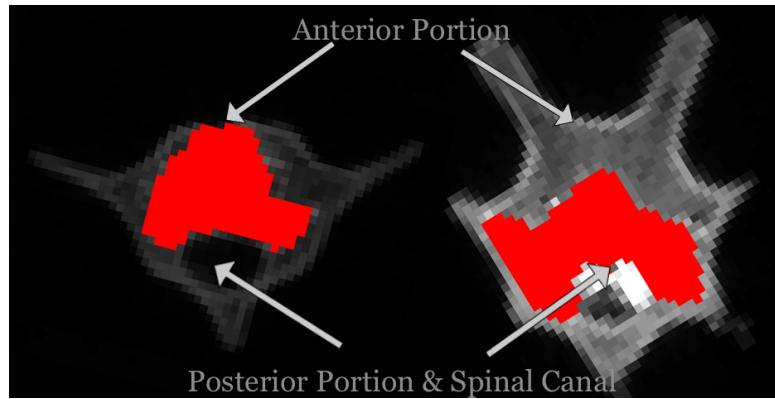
μ CT scans of T2-CC2 (left) and T8-CC2 (right), with cement masked in red, showing the extend of cement fill at the point where the cement was most anterior.
